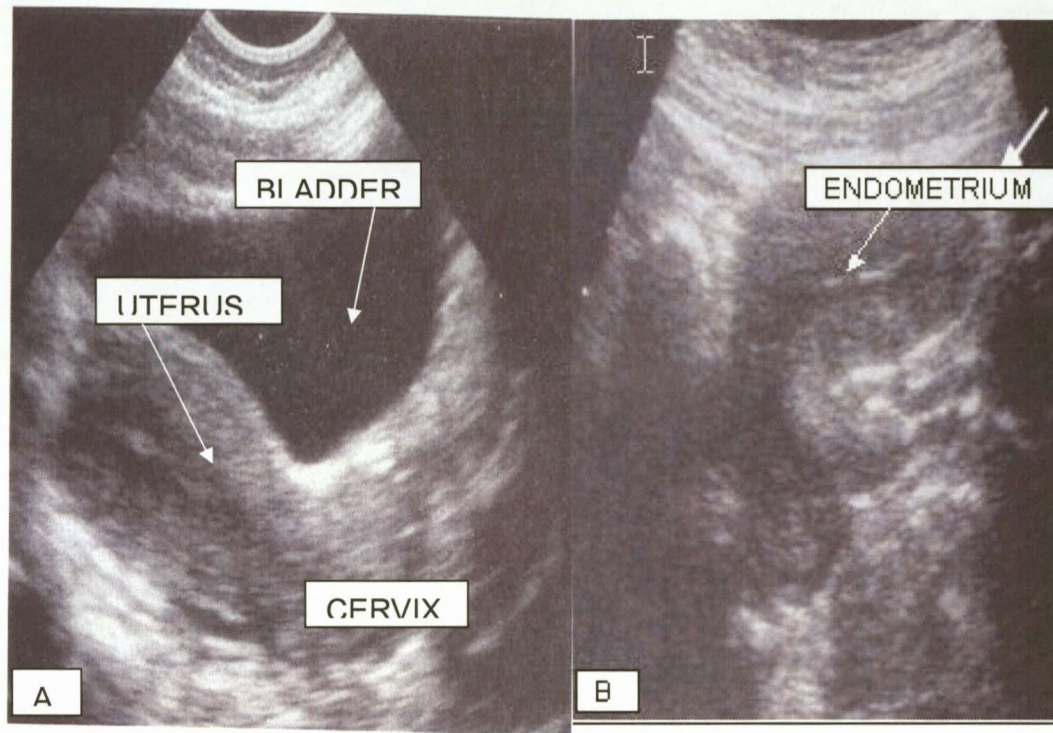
TRANSABDOMINAL ULTRASOUND SCAN OF UTERUS
